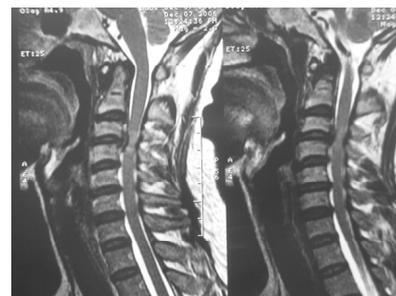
MRI of the cervical region showed remarkable anterior compression of the spinal cord at the levels of C3/4
